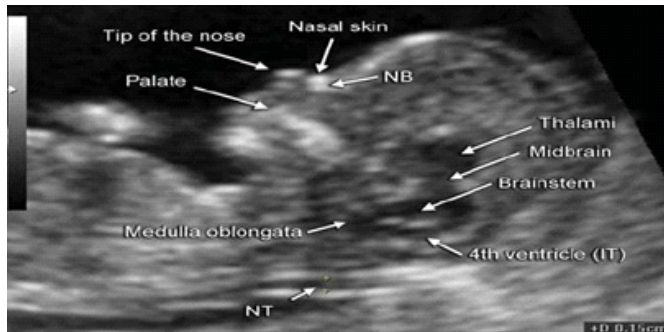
The fetal brain, face, and neck as shown by a two-dimensional ultrasound during the first trimester [9]
